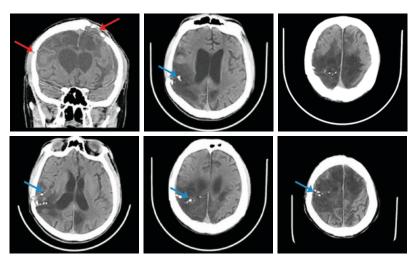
Standard CT scan with a very large area of frontal and parietal encephalomalacia with right predominance; also, compensatory ventricular dilation and the presence of bone fragments at multiple sites of the lesion (blue arrows). The entry and exit sites of the projectile in the skull (red arrows) are also shown.
